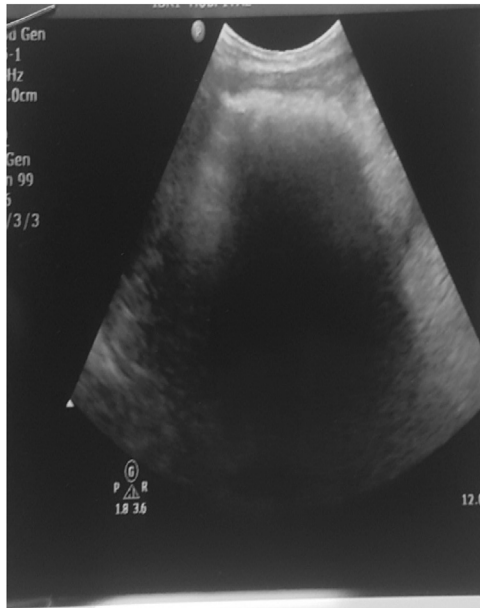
Ultrasound abdomen with large shadowing epigastric mass.
